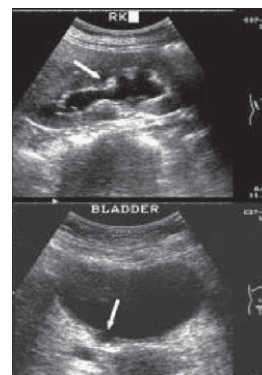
Ultrasound images depicting moderate right-sided hydronephrosis (arrow, upper frame) and an ulcer in the right posterior wall on transverse scan of the urinary bladder (arrow, lower frame). Note that the ulcer has a somewhat irregular, ragged, undermined edge.
